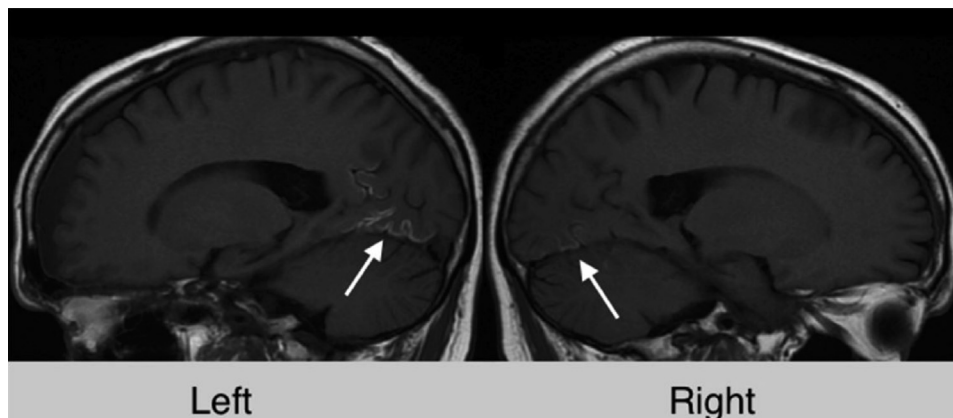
High signal in the occipital gyriform areas as shown by 2011 MRI scan of LH. Cortical laminar necrosis was reported in the bilateral posterior and medial occipital lobes and left inferomedial parietal lobe (Rivest et al., 2016).
